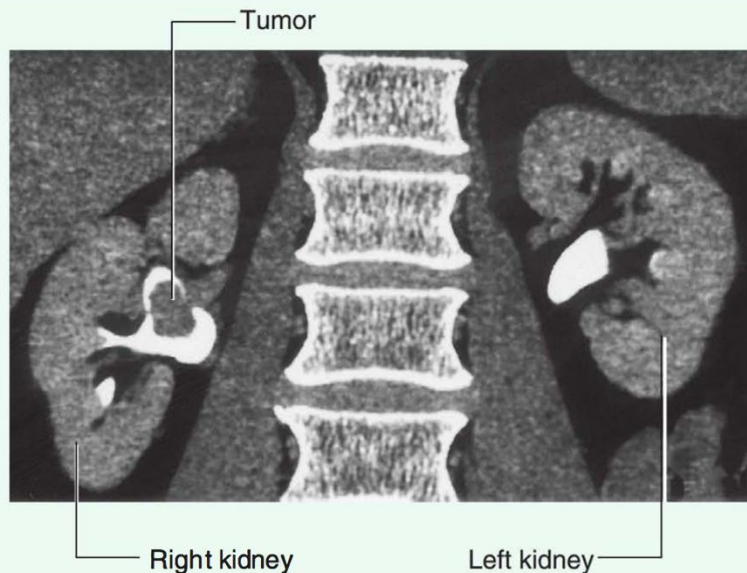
Transitional cell carcinoma in the pelvis of the right kidney. Coronal computed tomogram reconstruction.
